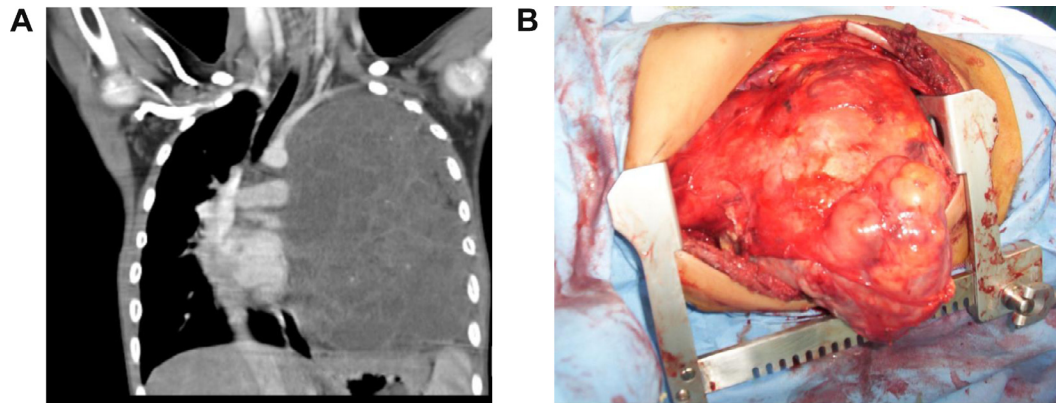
(A) CT. Coronal view of mediastinal GCT. (B) Intra operative view of extended lateral thoracotomy approach.
